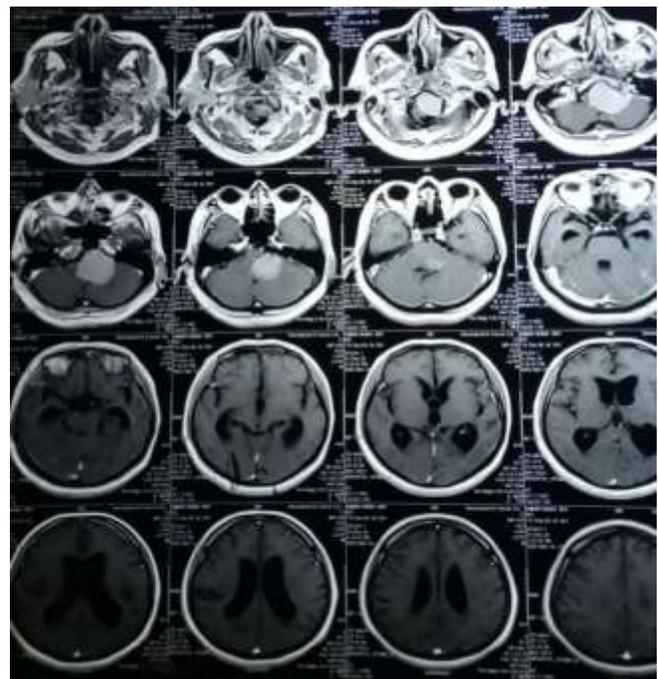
MRI brain showing that cerebellopontine (CP) angle tumor having a solid portion developing mild to moderate hydrocephalus.
